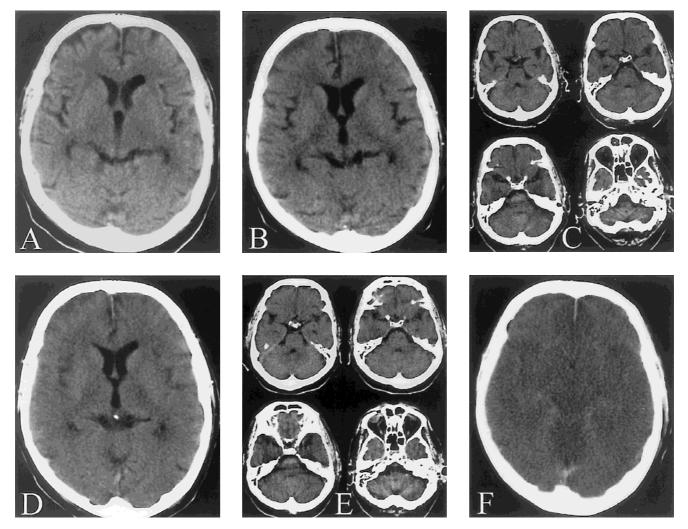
Case 1. Computed tomographic scans of a 52-year-old man with pneumococcal meningitis. (A) On day of admission (day 1), a normal cranial CT scan was obtained. (B) On day 3, a CT scan of the comatous patient 80 minutes prior to clinical herniation still did not reveal signs of severely raised ICP: no evidence of hydrocephalus or sulcal effacement was detected. Note minor changes such as reduction of gray-white matter differentiation or frontal sulcal effacement. (C) In addition, there was no obliteration of the basilar cisterns or other signs of impending cerebral herniation. (D) A second CT scan 150 minutes after the first and 70 minutes after clinical herniation now shows sulcal effacement and loss of gray-white-matter differentiation. (E) Remarkably, no radiological signs of cerebral herniation are present. A ventriculostomy was performed 100 minutes later which showed an ICP of 90 mmHg. (F) A massive global cerebral edema is visible 11 hours later.
